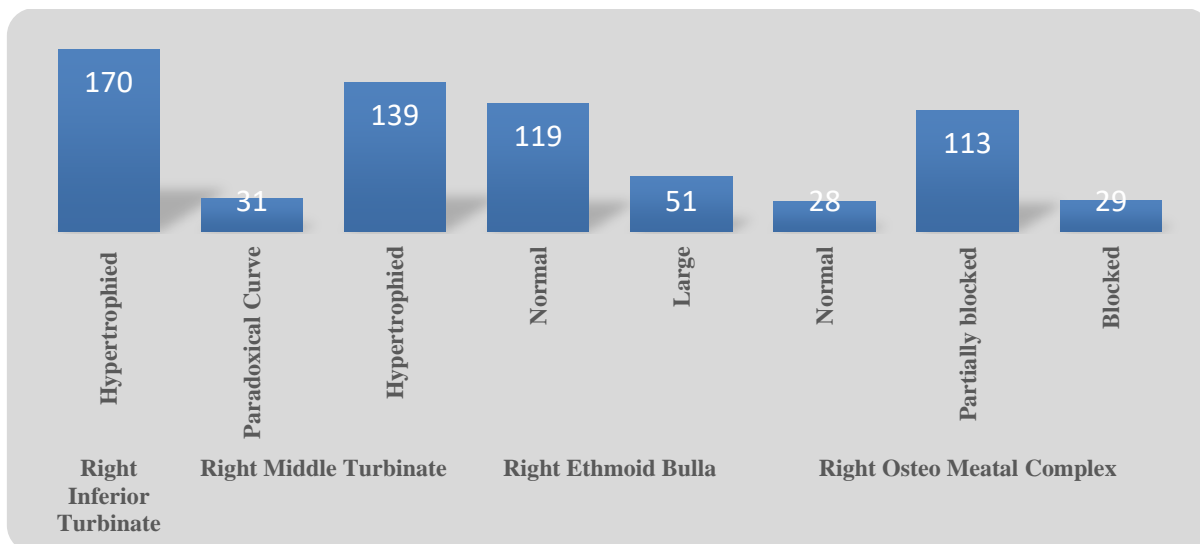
CT findings on right side of nose among rhinosinusitis patients
